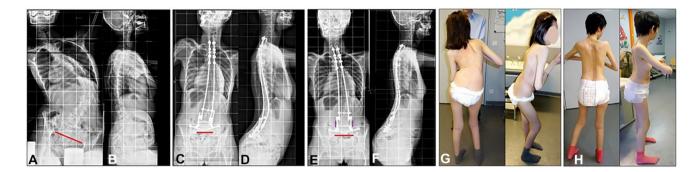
a–e Radiographs and photographs of an 11-year-old girl with Rett syndrome and 30° pelvic obliquity. a pre-operative radiographs. b 18 months post operatively (before rod lengthening). c 2.5 years
